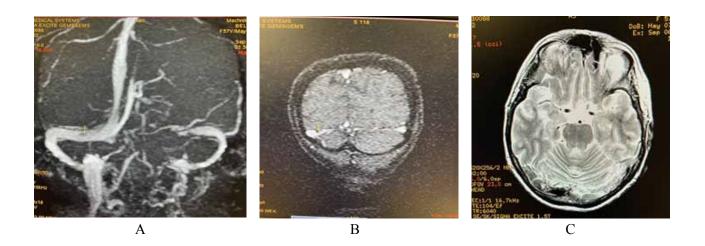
Magnetic resonance venographic signs with a suspected single thrombus in the right transverse sinus (A). However, considering the raw data (B) and the native T2-weighted image, these changes are arachnoidal granulations growing into the sinus (C).
